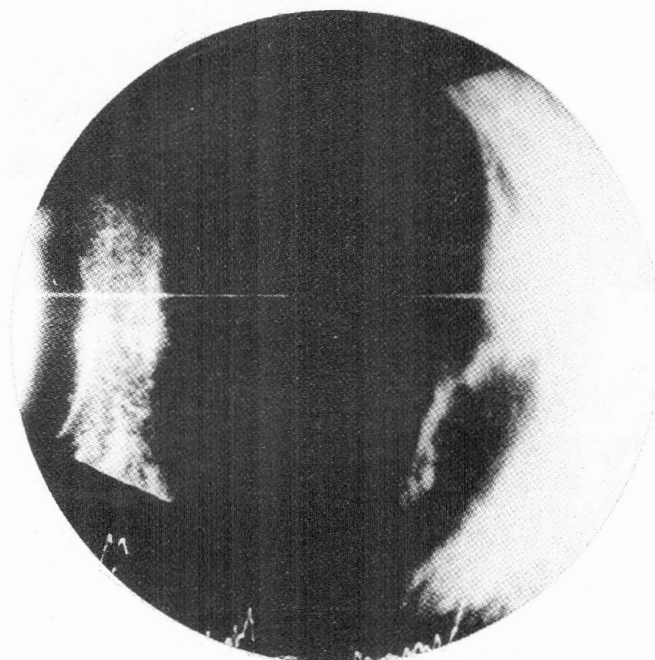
(Saatci, Gunenc, Tunc, Cingil): Initial B-scan ultrasonographic appearance of the mass with a concurrent inferior retinal detachment.
